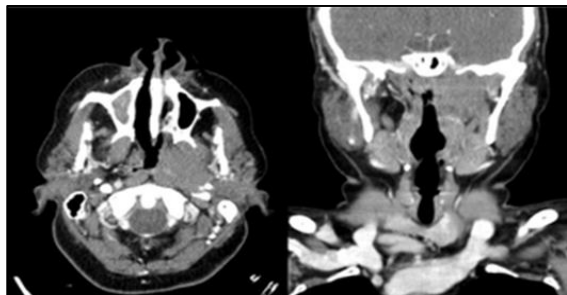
The axial and coronal CT of the patient.
